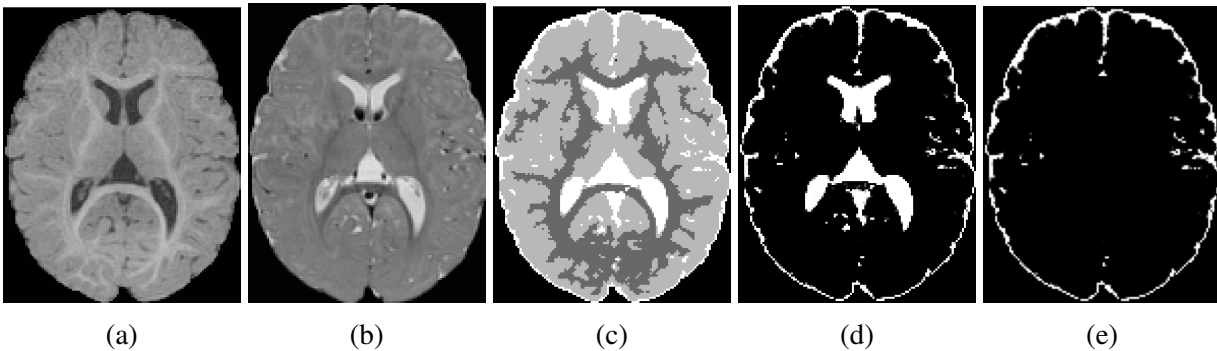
An example of the probabilistic tissue segmentation obtained for an input infant sMRI scan. (a) T1-weighted scan, (b) T2-weighted scan, (c) WM, GM, and CSF label map, (d) CSF probability map, (e) CSF probability map with ventricular CSF space removed.
